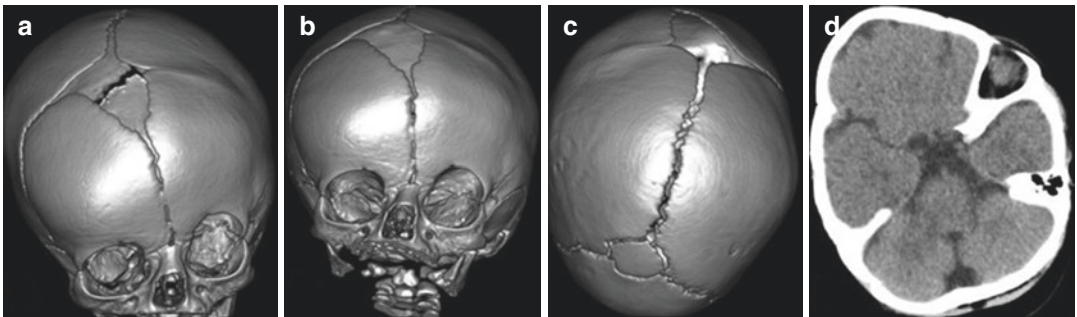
Left coronal suture synostosis in a 3-month-old baby. The patient was brought due to a deformity in her head. 3D CTs and CT scan show left coronal suture
